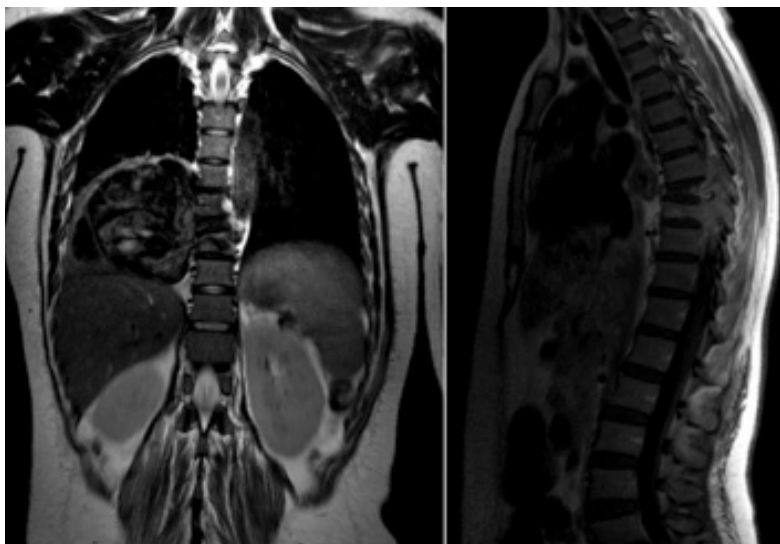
MRI of the dorsal spine, T2-weighted coronal plane and T1-weighted sagittal plane.
